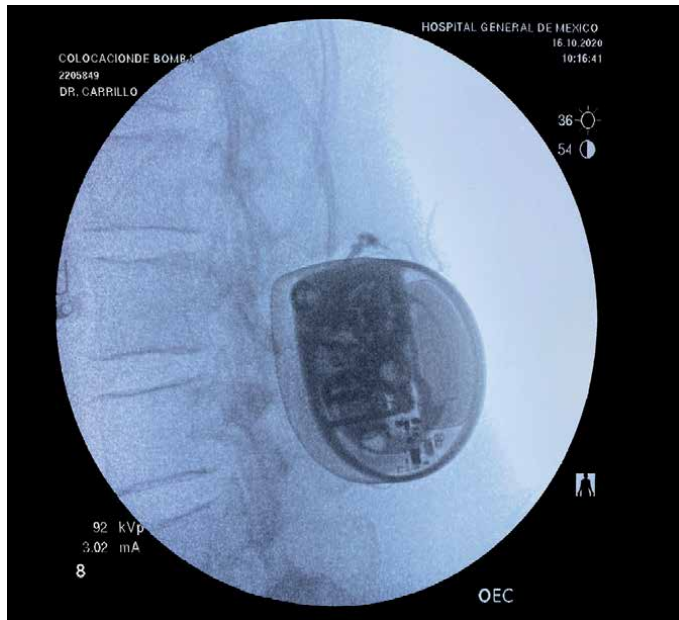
Post-operative picture of the pump immediately after the implantation surgery. X-ray image must be taken to verify the correct placement of the equipment.
